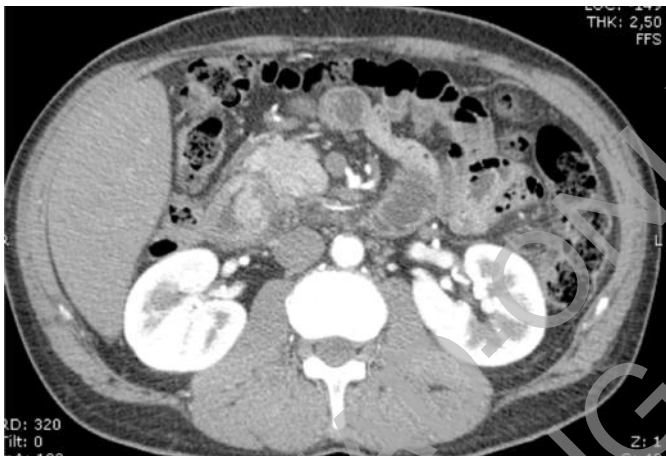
Case 2. MRI scan showing mass-like lesion with cysts of the groove.
